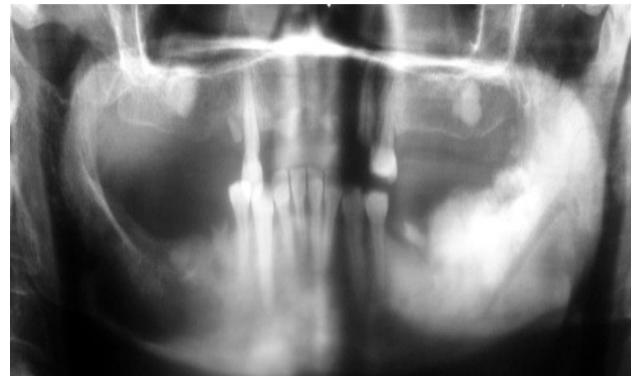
Panoramic radiograph depicting radiopaque masses in all the four quadrants of jaw with a large radiopaque mass in the left mandibular region extending from the first molar region and involving the left mandibular ramus.
